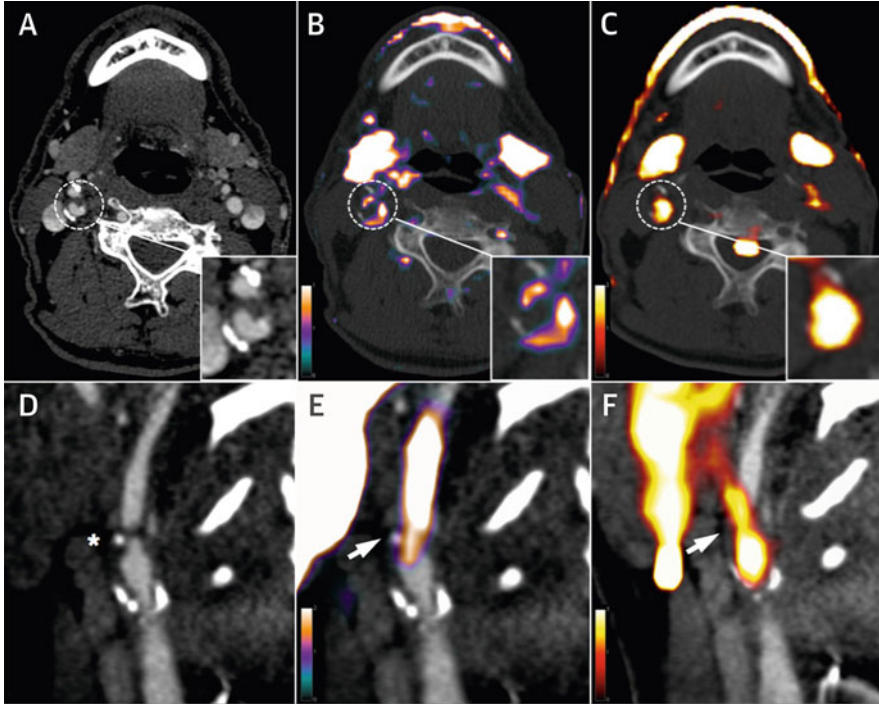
PET imaging of atherosclerosis with $[^{68}\text{Ga}]\text{Ga-DOTATATE}$ and $[^{18}\text{F}]\text{FDG}$. Views from a 66-year-old man (top, axial plane) and a 70-year-old man (bottom, sagittal plane), both of whom had transient ischemic attacks resulting from right internal carotid artery lesions with intense culprit plaque inflammation (hatched circles in a–c and */arrows in d–f). (a and d) CT. (b and e) PET/CT imaging with $[^{68}\text{Ga}]\text{Ga-DOTATATE}$. (c and f) PET/CT imaging with $[^{18}\text{F}]\text{FDG}$. Reproduced from [69] under CC-BY-4.0 license. © 2017, Tarkin et al.
